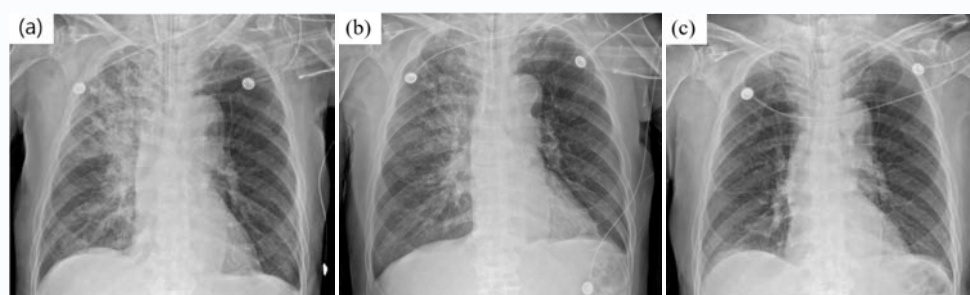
The patient's chest radiograph finding. Postoperative day 1 (a), day 3 (b), day 12 (c).
